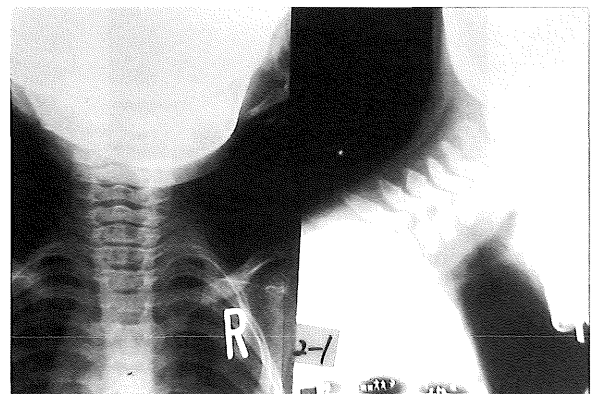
Case 1 – a plane roentgenogram taken at the age of 3 revealed no sign of dislocation or fracture. (3 years)
